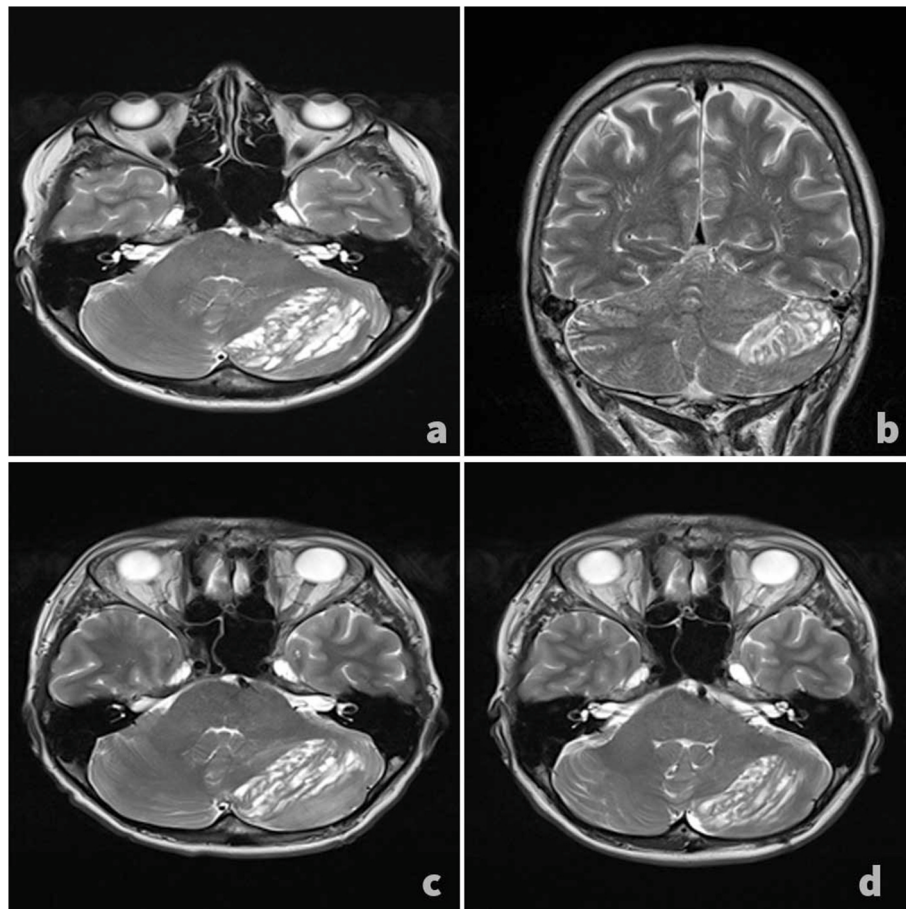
The cerebellar cortex was unilaterally altered left, with a characteristic striate, laminar tiger pattern easily noticeable on preoperative native T-2 weighted (a) MRI scan, as well as on coronal reformation (b), which was indicative of dysplastic cerebellar gangliocytoma. Immediate postoperative T-2 weighted axial MRI brain scan revealing partial tumor resection, resulting in the relief of the mass effect on the posterior fossa (c). A postoperative T-2 weighted axial MRI brain scan of the same patient performed 10 years after surgery revealing no signs of tumor relapse and disease progression.
